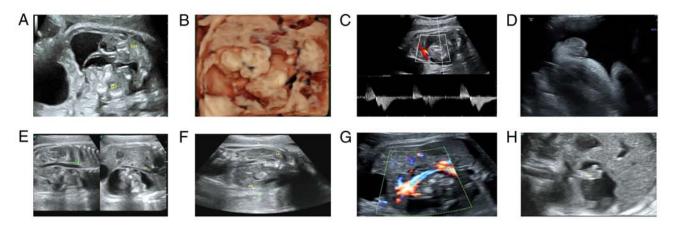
US of FIF. (A) US of the twin FIF in the abdominal cavity of the host fetus. (B) Surface image of the FIF in the abdominal cavity of the host fetus. (C) The spectrum of the heartbeat of the FIF in the abdominal cavity of the host fetus. (D) Limb image of the FIF in the abdominal cavity of the host fetus. (E) The abdominal aorta and inferior vena cava of host fetus were compressed and shifted inferiorly. (F) The position of the right kidney of the host fetus was relatively low and closely adjacent to the bladder. (G) The right renal artery originates from the abdominal aorta of the host fetus. (H) Ultrasound scan of the fetal genitals. US, ultrasonography; FIF, Fetus in fetu.
